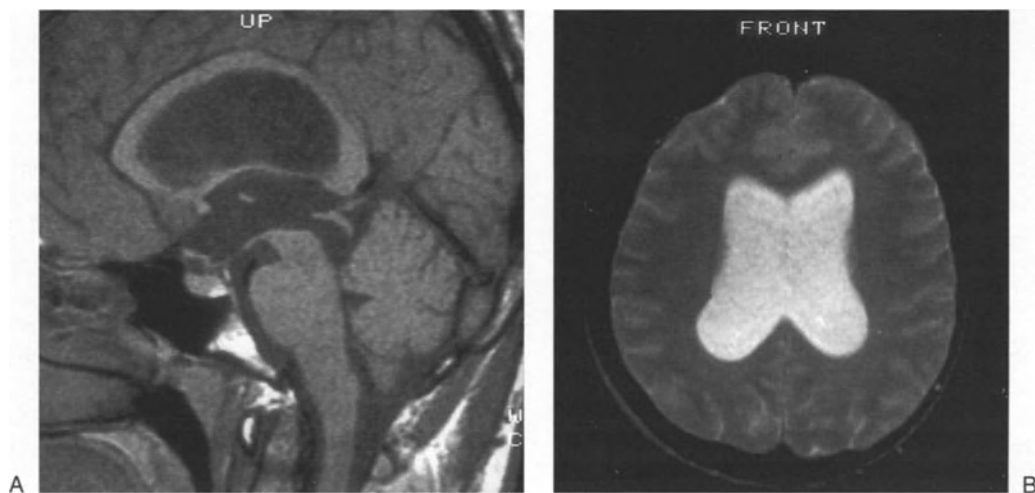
This is a most interesting case: idiopathic triventricular hydrocephalus *without* occlusion of the aqueduct. In fact, the aqueduct is remarkably dilated. (A) A sagittal SE600/15 image and (B) an axial SE2400/90 image are MRI studies performed electively after the ventriculomegaly was revealed
